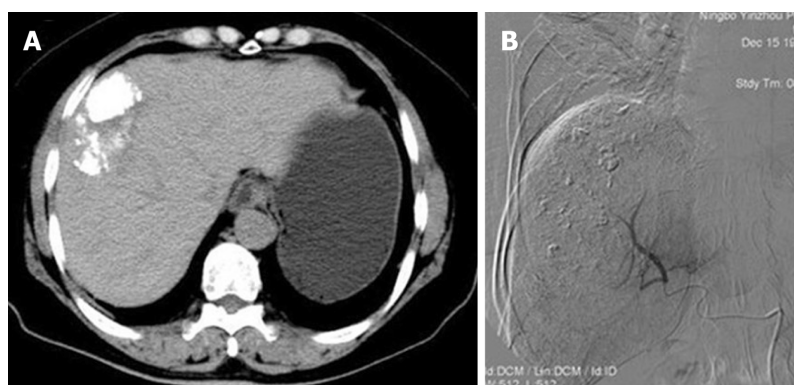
Imaging changes after treatment. A: Computed tomography showed significant tumor shrinkage associated with satisfactory lipiodol deposition; B: No newly emerging lesions and successful embolization of feeding arteries.
